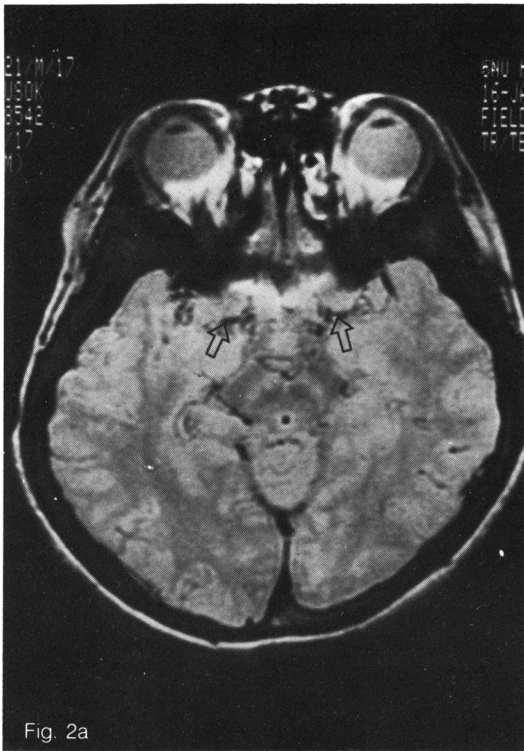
Axial MR images (SE 2500/30/1) of a 17-year-old male showing abnormalities of horizontal portions of both middle cerebral arteries and collateral vessels. Only short segments of the horizontal portions (open arrows) of both middle cerebral arteries are visualized (a). Multiple signal void collateral vessels (arrows) are well demonstrated in the basal ganglia (b), parietal cortical areas and periventricular white matter bilaterally and in the frontal cortex on the left (c).
